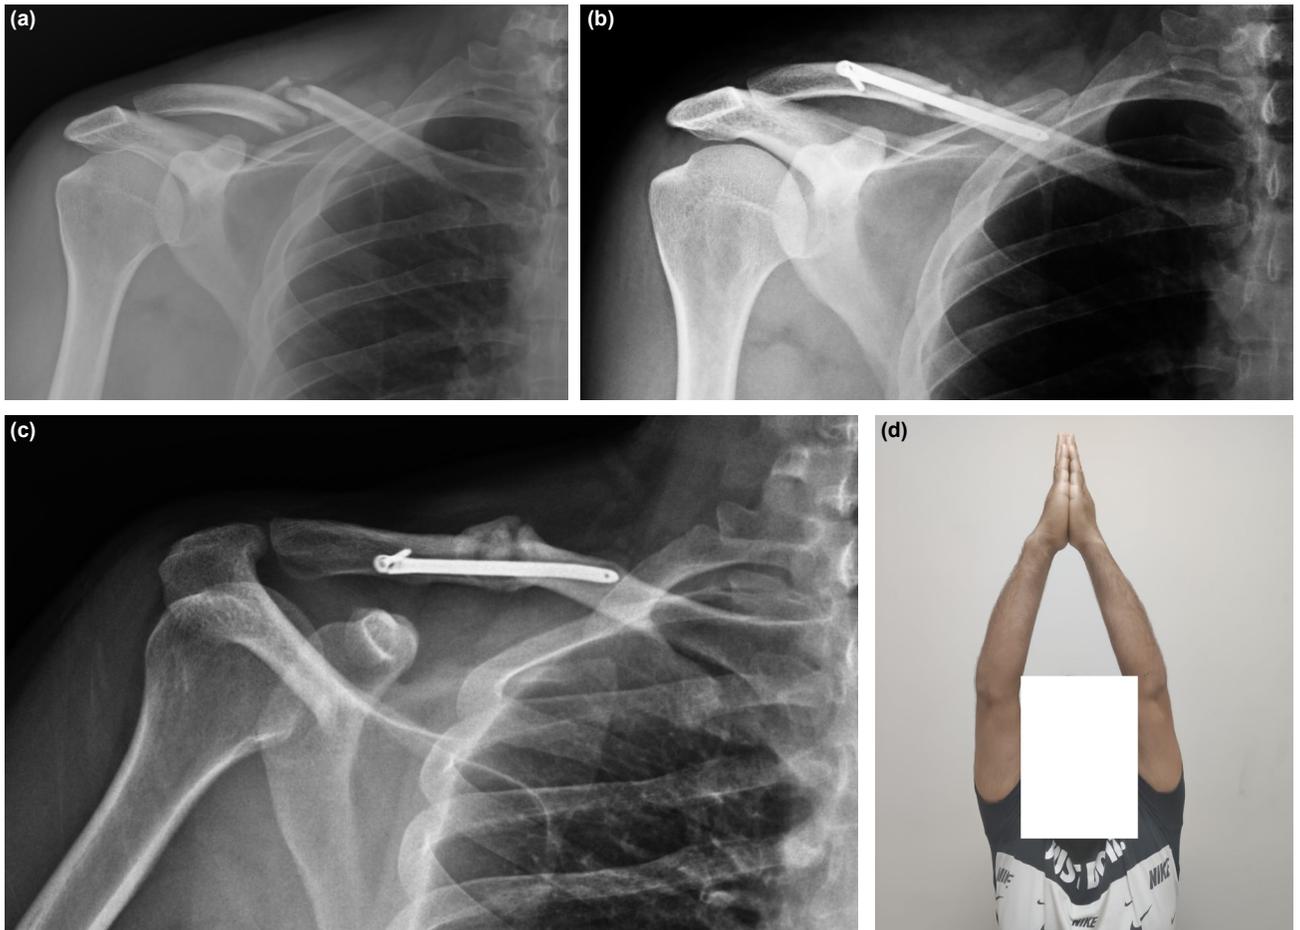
(a, b) Pre-operative and post-operative early anteroposterior X-rays of a 33 year-old male, who sustained a wedge fracture of right clavicle, (c) 1 year post-operative anteroposterior X-ray after union, and (d) clinical image of same patient.
